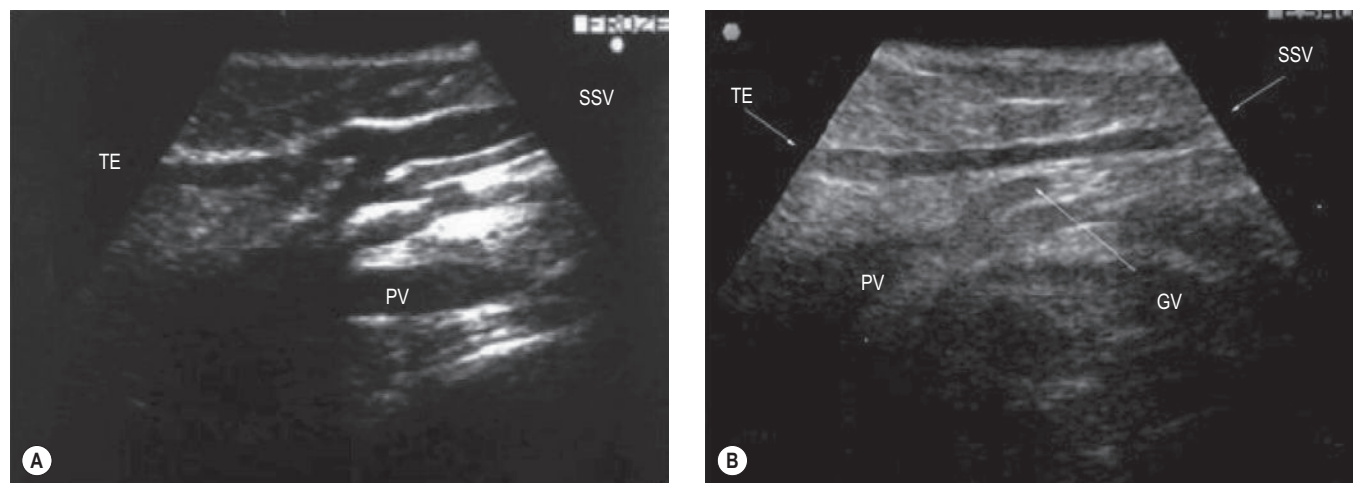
Ultrasound imaging aspects of small saphenous vein (SSV)–popliteal arrangement. A, The SSV extends into the thigh in about 50% of cases; in one third of these the SSV joins the popliteal vein and then continues up into the thigh (B), whereas in the remaining two thirds of cases the SSV continues into the thigh without any connection with the popliteal vein (PV). TE, Thigh extension.
